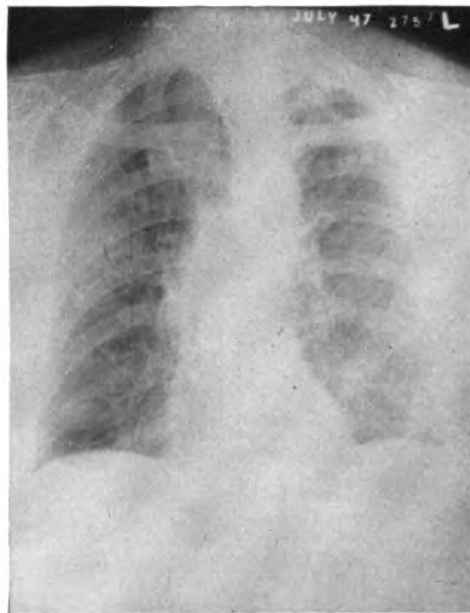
Case 2. Roentgenogram taken 12 weeks after discharge from treatment. There is slight residual thickening of the pleura in the lower third of the left hemithorax. The left costophrenic angle is partially obliterated.
